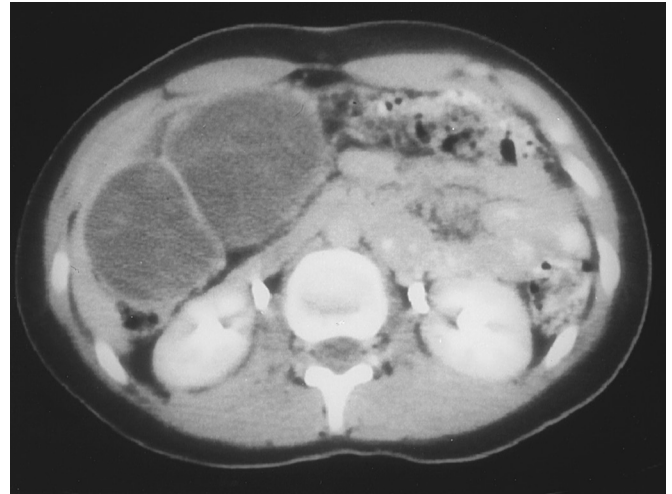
Computed tomographic scan of the abdomen in an 11-year-old boy, showing a mesenteric cyst in the transverse mesocolon.
